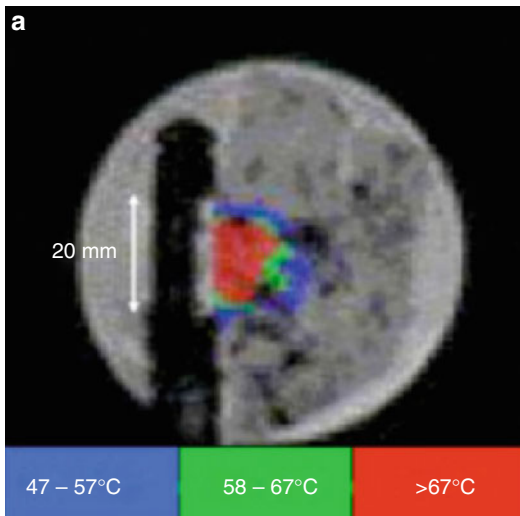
Examples of HIFU guided by MRI: (a) temperature measurement to control the treatment of esophagus tumors (Beerlage et al. 1999)
